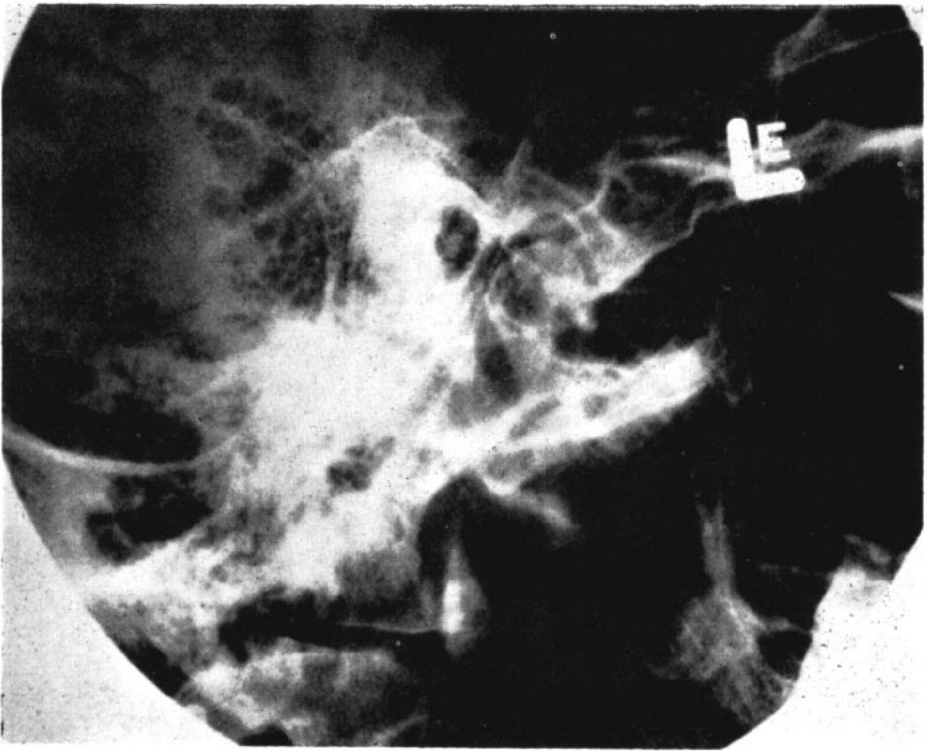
Lateral temporomandibular x-ray—Reveals joint structures but introduces distortion, lack of orientation planes and area does not include teeth and mandible.
